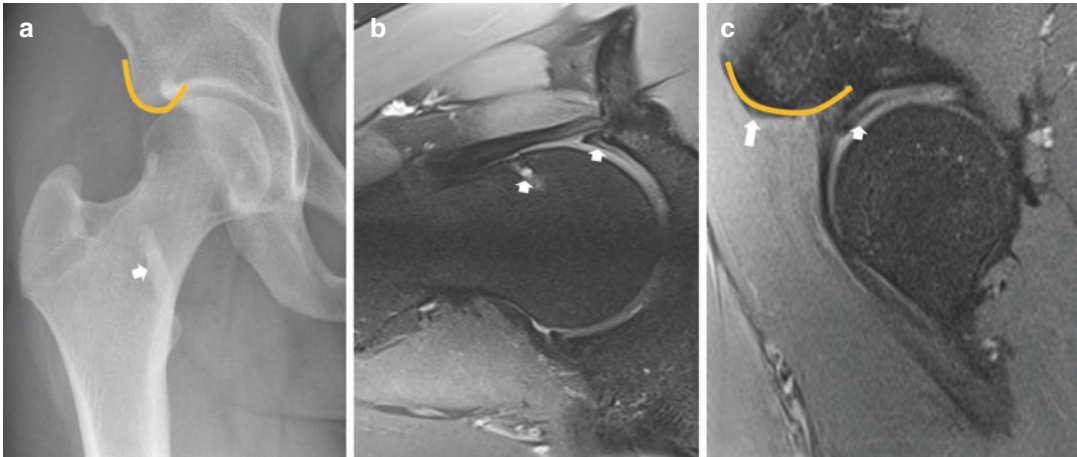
(a–c) Male soccer player, 25 years old. Right subspine impingement. (a) Right AP hip radiograph showing a prominent AIIS (orange line) with caudal extension below the acetabular rim level (type 3). Also, heterotopic ossifications are seen in the path of the *rectus femoris* muscle (white arrow). (b) Radial fat-suppressed
